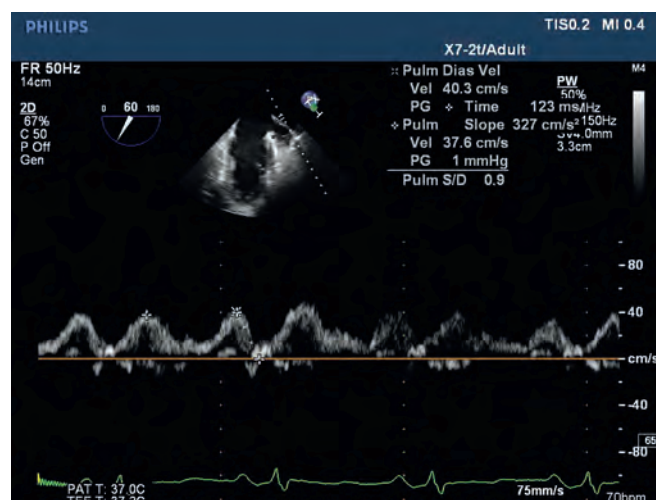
Pulsed-wave Doppler echocardiographic S and D waves from the left upper pulmonary vein in a patient with abnormal left atrial pressures. Deceleration time of the D wave is 123 milliseconds in this example. Diast, diastolic; FR, frequency; PG, pressure gradient; Pulm, pulmonary; PW, pulsed-wave; Vel, velocity.
